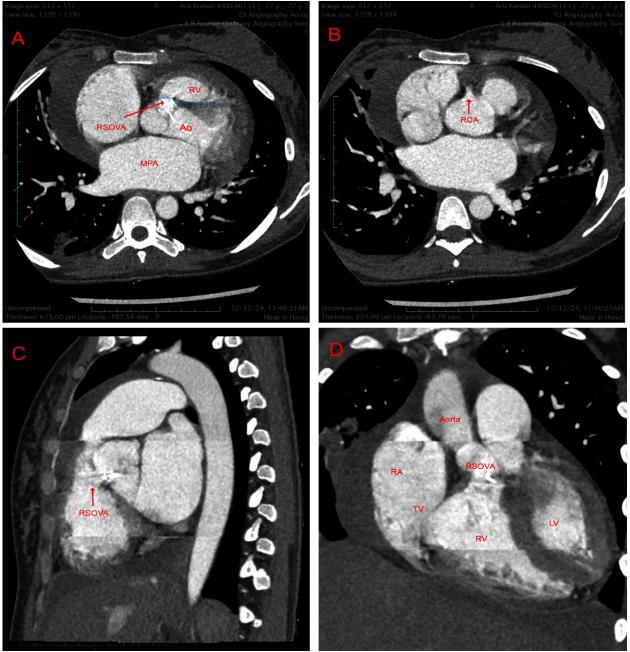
CT angiogram images. A) Axial section showing RSOVA, measuring 9.2mm arising from right coronary cusp communicating with RV; B) main Pulmonary Artery (MPA) is mildly dilated; C) axial section showing origin of right coronary artery (RCA), confirming the rupture in right coronary cusp; D) saggital and coronal sections delineating the site of rupture. Mild pericardial effusion was also noted.
